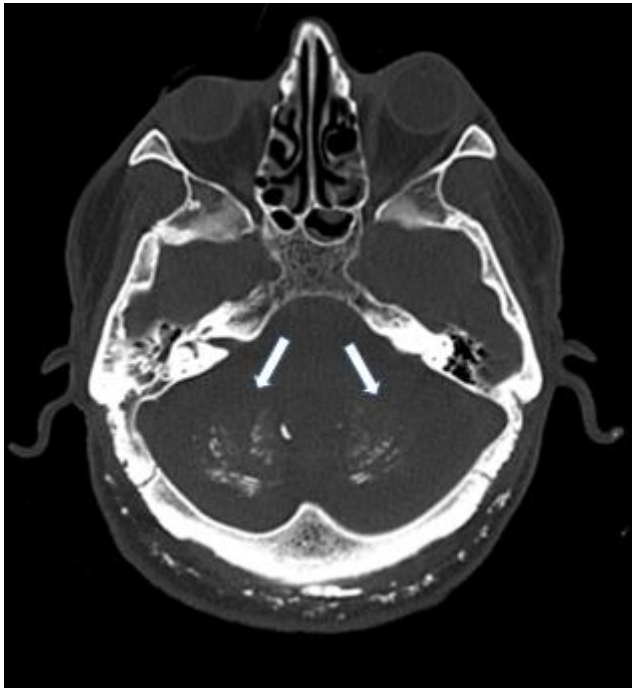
Calcification of bilateral caudate nucleus, putamens and cerebellum is documented in brain CT scan.
